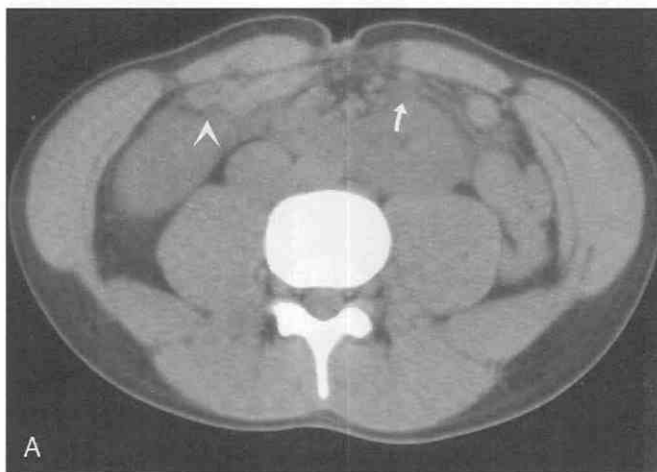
Non-contrast renal CT protocol. A, Axial image shows left ureteric dilatation (arrow); compare it with contralateral ureter (arrowhead) in a patient with horseshoe kidney. He had a small left ureterovesicular calculus (not shown). B, Right perinephric stranding (arrow) secondary to distal ureteric calculus (not shown).
